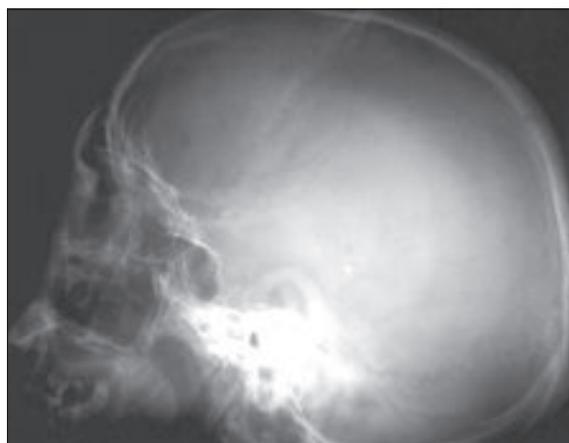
X-ray of skull showing lytic lesions.
